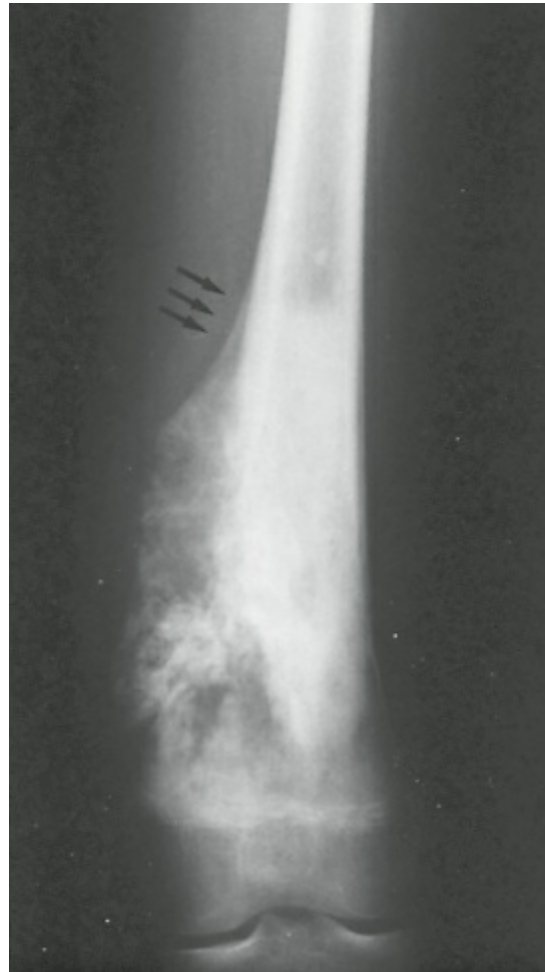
Plain radiograph of the femur showing a high-grade osteosarcoma. The tumor is an ill-defined destructive lesion with an extensive soft tissue involvement. Codman triangles (*arrows*) indicate periosteal reaction, which are characteristic, but not pathognomonic, of osteosarcoma.
